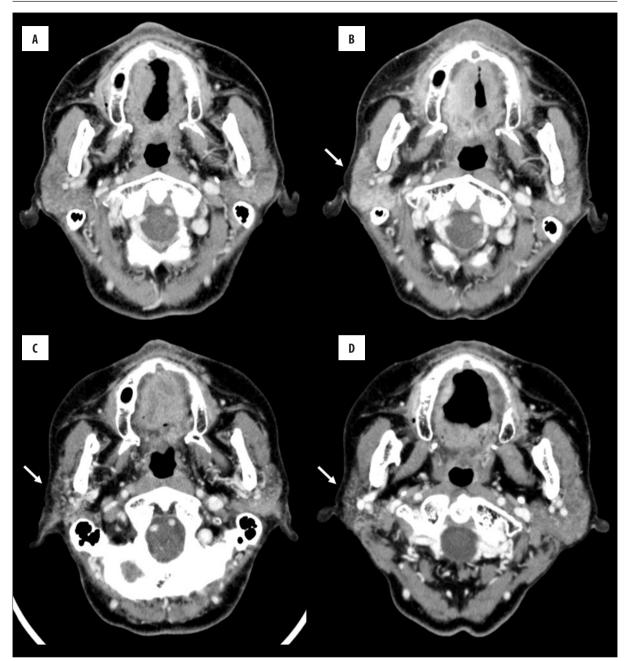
A 70-year-old female with right-sided maxillary carcinoma after radical irradiation (total 66Gy). Radiation dose applied to the right and left parotid glands was 20 Gy and 0 Gy, respectively. (A) CT before radiotherapy shows no difference between the right and left parotid glands. (B) Contrast-enhanced CT performed immediately after radiotherapy shows high-density changes in the right parotid gland (arrow). (C) CT performed 2 years after radiation therapy shows low-density changes (fat degeneration) and parotid shrinkage in the right parotid gland (arrow). (D) CT performed 3 years after radiation therapy shows low-density changes (fat degeneration) and parotid shrinkage in the right parotid gland (arrow).
